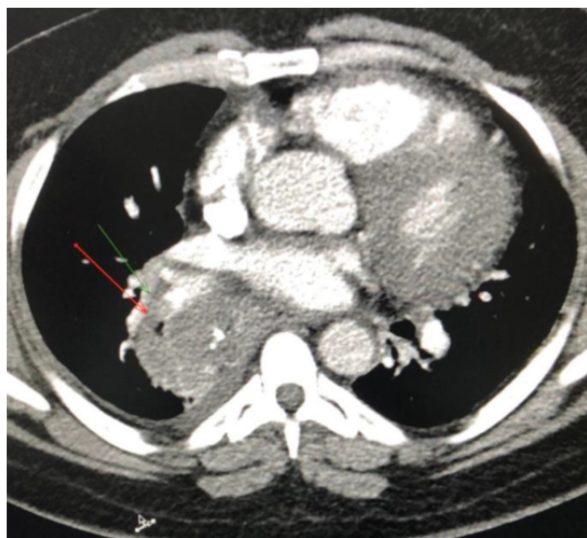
CT chest and abdomen with contrast on admission showed Rt. sided lower lobe mass with bronchial obstruction (bronchus intermedius) and pulmonary embolism at same side.
